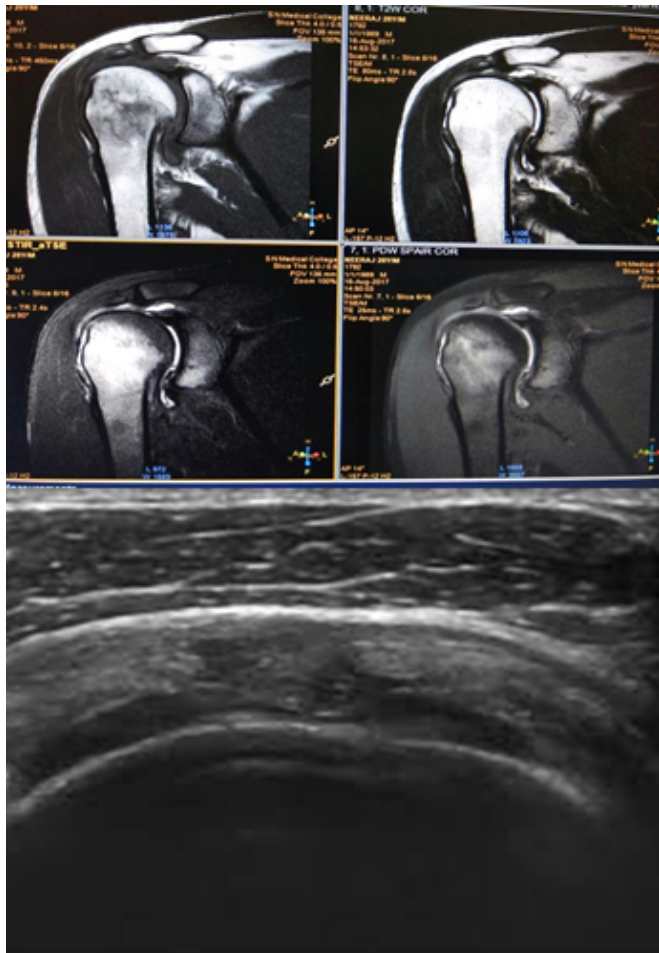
MRI Coronal(A)T1(B)T2(C)Stir (D)PDW images showing complete chronic SUPRASPINATUS with proximal tear retraction and atrophy of muscle (E)On USG complete tear of supraspinatus
